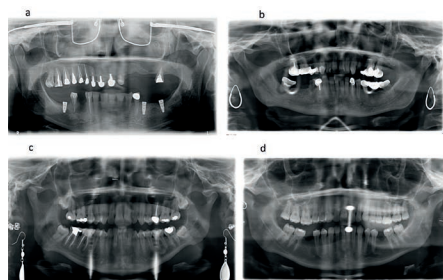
Personal objects in panoramic radiographs: a) glasses b) earrings c) earrings d) lingual piercing
